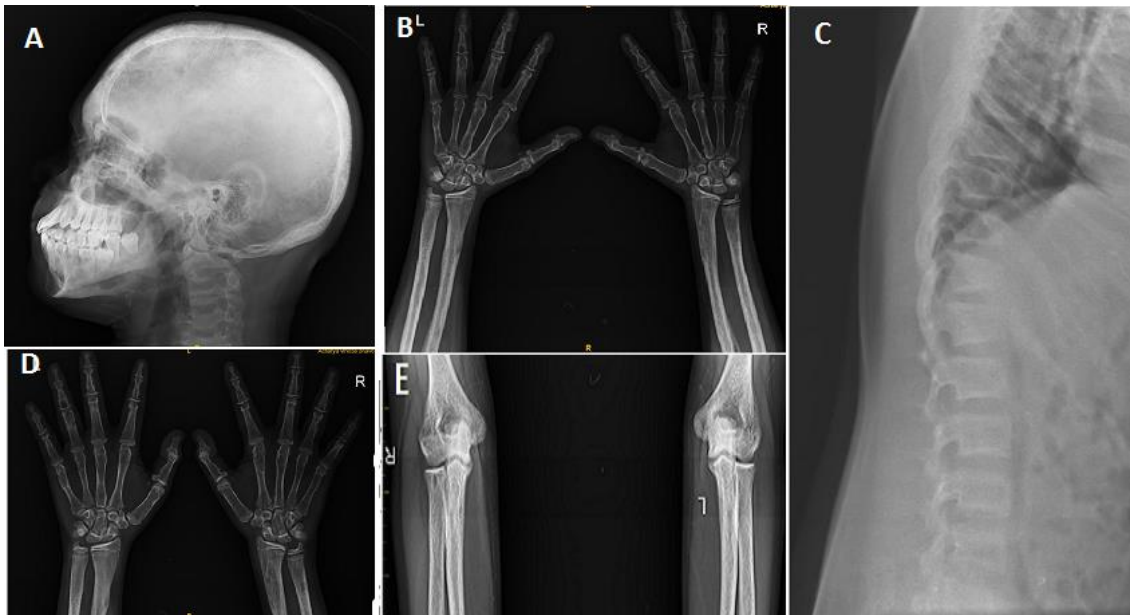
A) lateral view of plain X-ray of skull suggestive of softening and thinning of the cranial bones, particularly in the occipital area at the back of the skull, X-rays may reveal areas of thinning and increased translucency; B) anteroposterior view of plain X-ray of bilateral wrist suggestive of widened growth plate, fraying and cupping of the distal radius and ulna, metaphyseal fraying and splaying seen; C) lateral view of plain X-ray of dorsolateral spine suggestive of Rachitic rosary (beaded appearance on X-rays), cupping and flaring of the rib ends, thin and undermineralized rib cortex; D) anteroposterior view of plain X-ray of bilateral hand suggestive of widened growth plate, cupping and fraying of the metaphysis; E) anteroposterior view of plain X-ray of bilateral elbow suggestive of widened growth plate, cupping and fraying of the distal humerus and proximal radius and ulna, metaphyseal fraying and splaying
